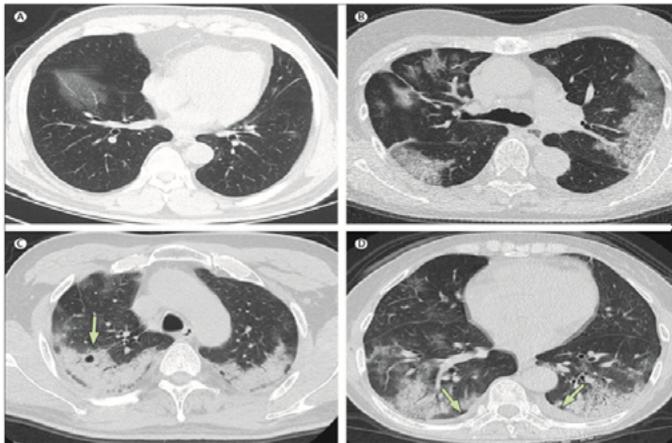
Transverse thin-section CT scans in patients with COVID-19 pneumonia (A) 50-year-old man, day 3 after symptom onset: focal ground-glass opacity associated with smooth interlobular and intralobular septal thickening in the right lower lobes. (B) 74-year-old woman, day 30 after symptom onset: bilateral, peripheral ground-glass opacity associated with smooth interlobular and intralobular septal thickening (crazy-paving pattern). (C) 61-year-old woman, day 20 after symptom onset: bilateral and peripheral predominant consolidation pattern with a round cystic change internally (arrow). (D) 63-year-old woman, day 17 after symptom onset: bilateral, peripheral mixed pattern associated with air bronchograms in both lower and upper lobes, with a small amount of pleural effusion (arrows).
